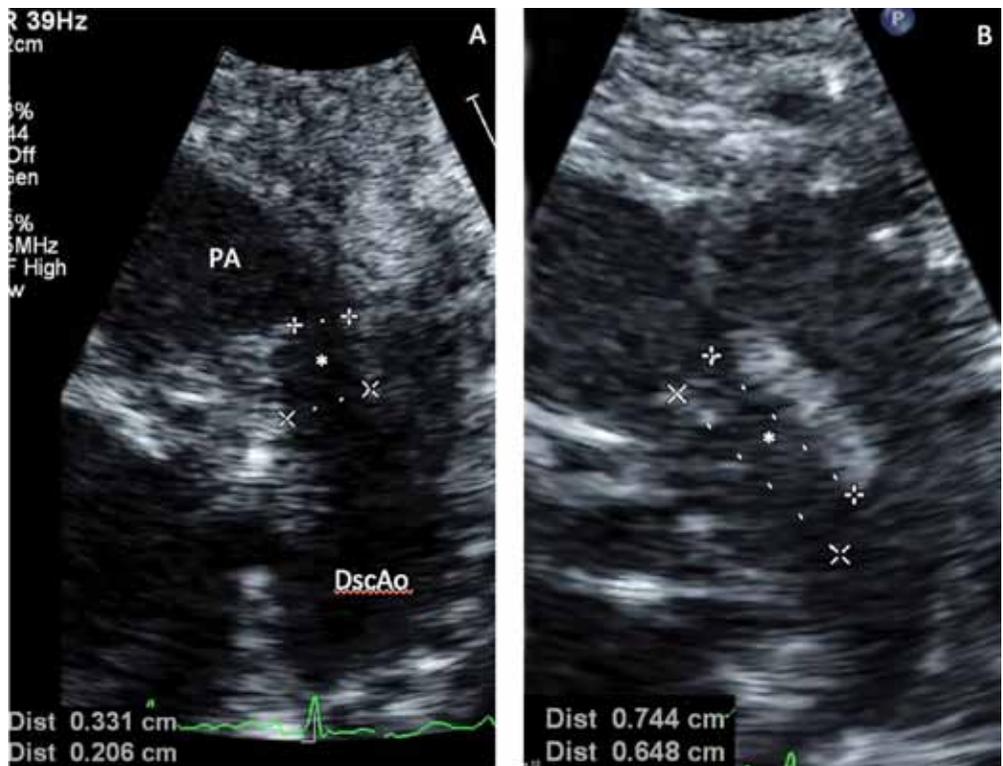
Two-dimensional transthoracic images of the pertinent anatomy obtained from the high left parasternal position. The PDA (*) diameters (A) and length (B) from the pulmonary artery (PA) to descending aorta (DscAo) are measured to determine candidacy for transcatheter device closure. With a minimum PDA length > 6 mm and narrowest diameter of 2 mm, this patient was selected for device closure and a 3 mm AVPII was successfully implanted.
